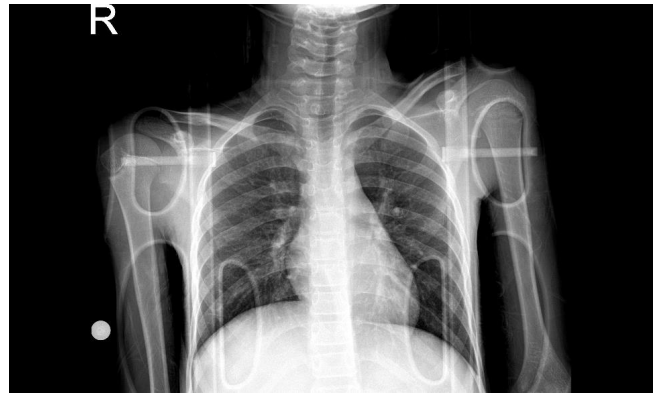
Bedside antero-posterior lung radiography of the patient. Irregularity of cortical bone in the lateral 1/3 of the right clavicle.
